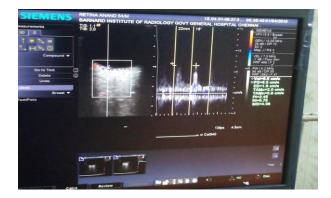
Colour Doppler imaging for Resistive Index. Image courtesy: Rajiv Gandhi General Hospital, Chennai.
